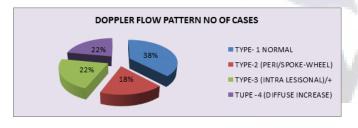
Doppler Flow Pattern
